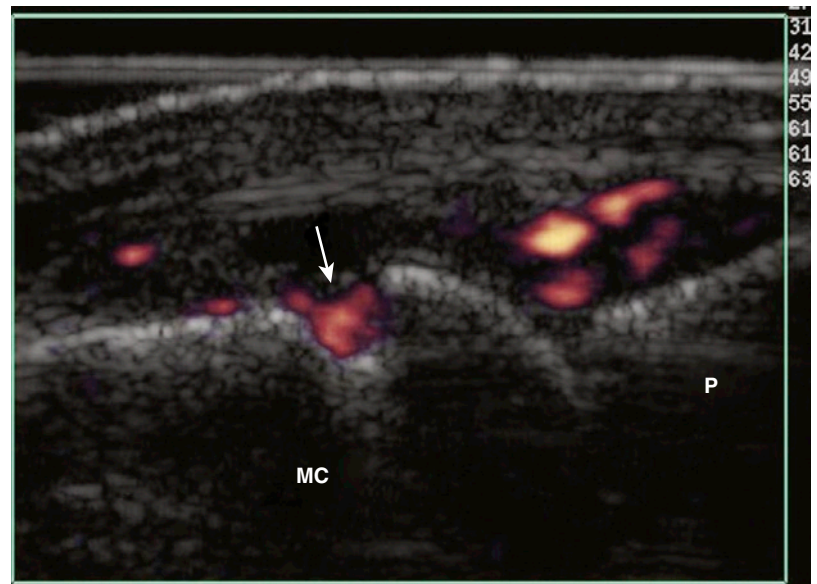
IMAGING OF THE METACARPOPHALANGEAL JOINT. Longitudinal section through the dorsal aspect of a second metacarpophalangeal joint shows increased Doppler signal in the joint and an erosion (arrow). MC, metacarpal; P, phalanx.
